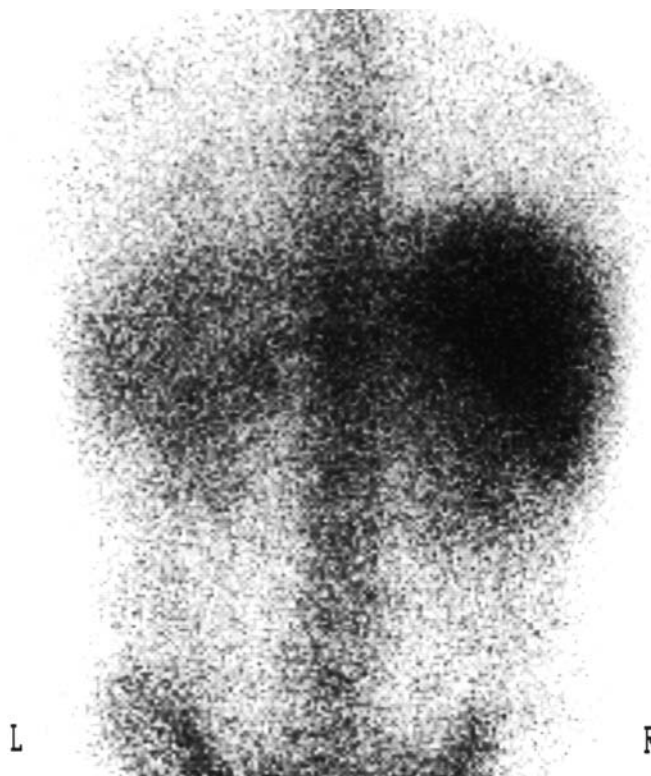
Strong inflammation in both kidneys is shown by ⁶⁷Ga citrate whole-body scintigram
